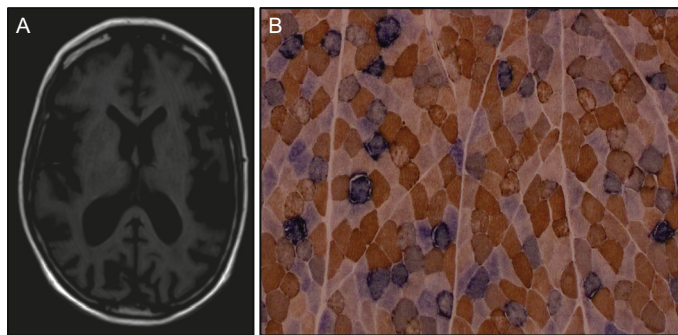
MRI and histochemical findings: (A) cMRI (t1) showing generalised brain volume reduction. (B) Histochemical demonstration of sequential COX and SDH activities revealing numerous COX-deficient (blue reaction product) fibres and evidence of subsarcolemmal mitochondrial proliferation.
